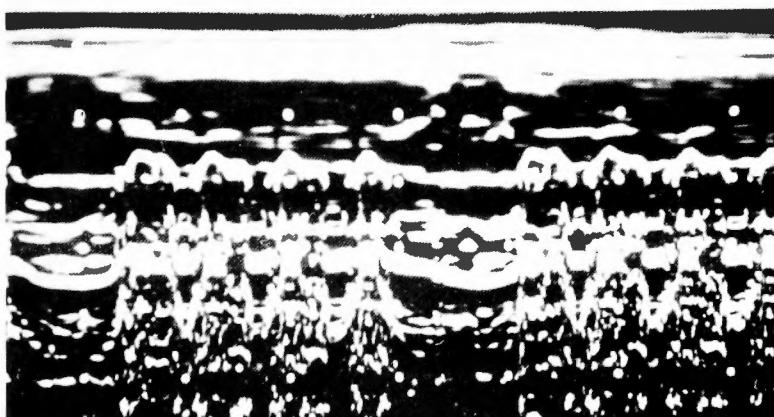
Postoperative echocardiography (Patient 4)
